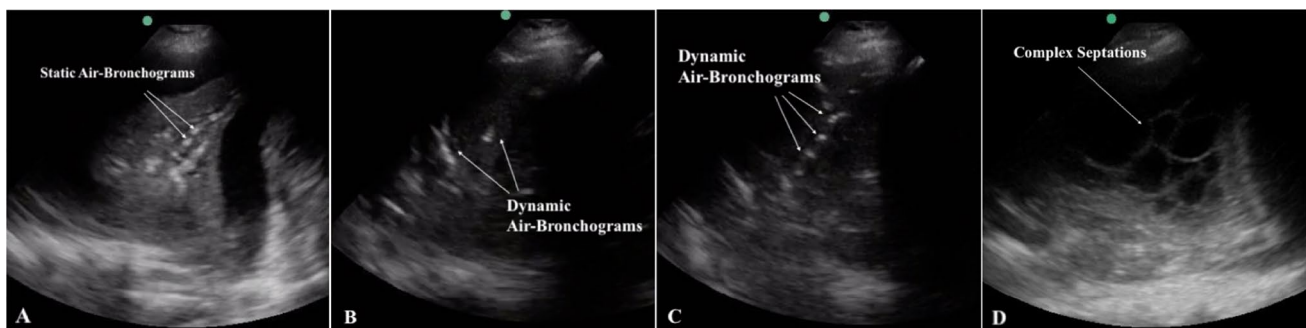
Sonographic signs of Pneumonia and Pleural Diseases. a Punctate hyperechogenic spots (arrows) are visualized within consolidated lung that do not move with respiration identifying static air-bronchograms, suggestive of resorptive atelectasis though pneumonia is also possible; b, c) Dynamic air-bronchograms are identified by a
